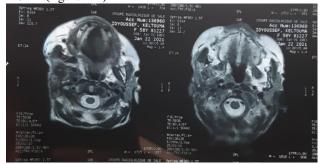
CT image showing right parotid process
